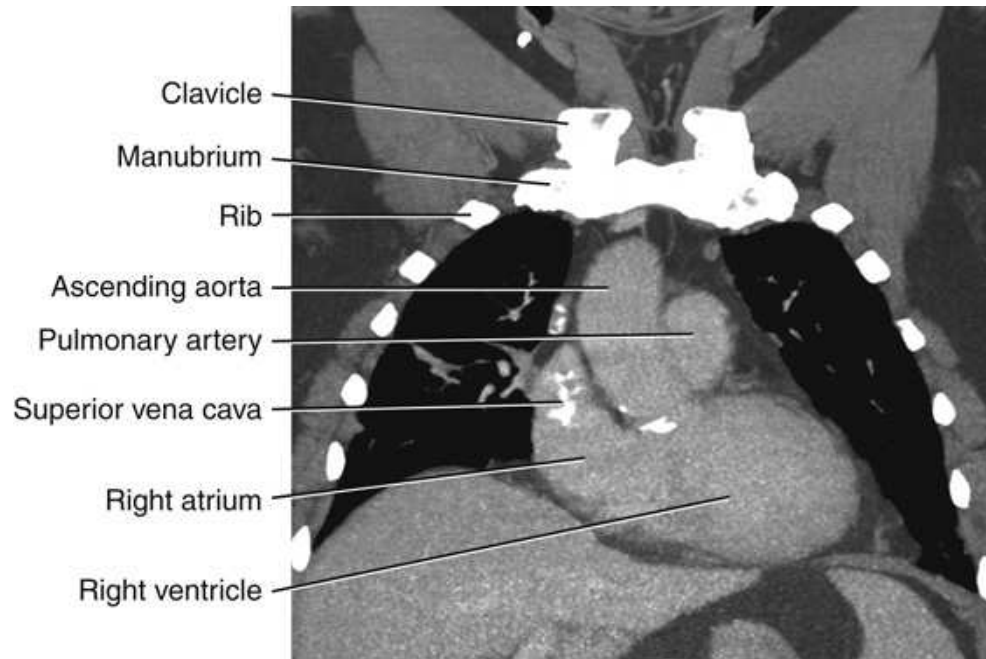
Coronal CT image of thorax corresponding to level *A* in Fig. 24.43.
